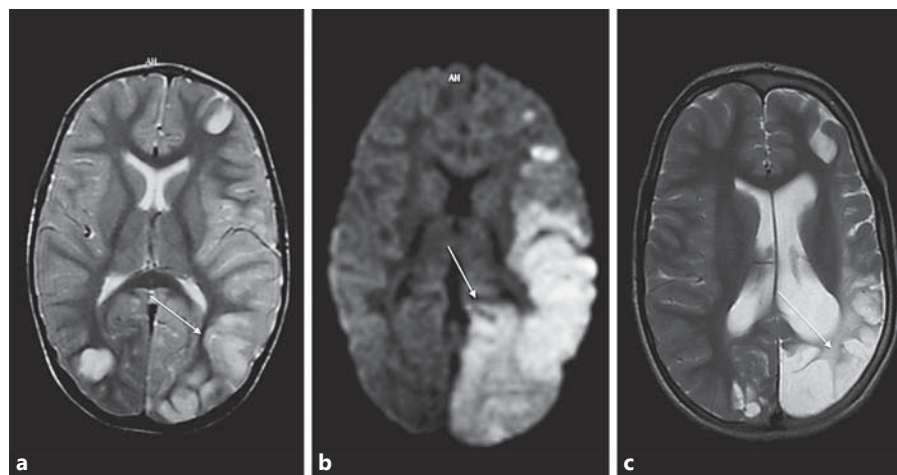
Brain imaging studies of patient 1. a Cortical diffusion restriction in diffusion-weighted imaging in the left parietal lobe (arrow). b Follow-up 3 months later. Cortical hyperintensity in T2-weighted imaging in the same area with volume loss (arrow).
